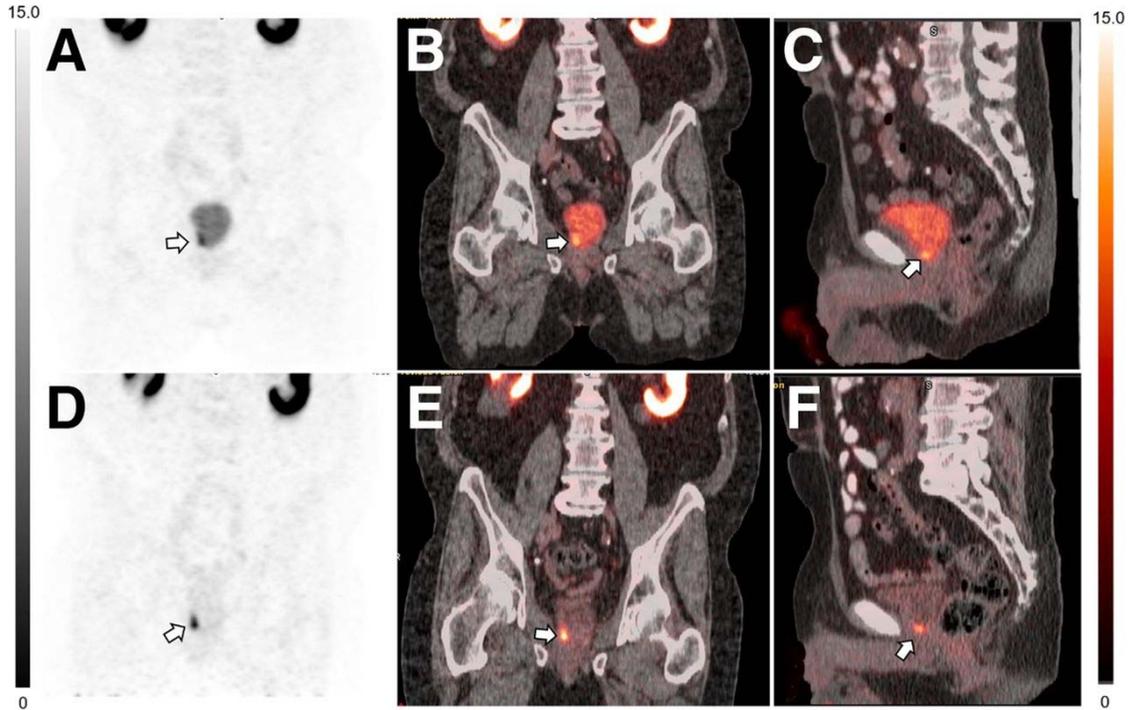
^{18}F -flotufolastat PET/CT obtained without (A–C) and with (D–F) furosemide in 78-y-old man with PSA of 2.98 ng/mL after radical prostatectomy. Both sets of images demonstrate focus of increased radiotracer uptake in right lateral resection margin consistent with prostate bed recurrence. Although lesion is seen on both sets of studies, it is more conspicuous on with-furosemide study. He received sRT, and PSA became undetectable.
